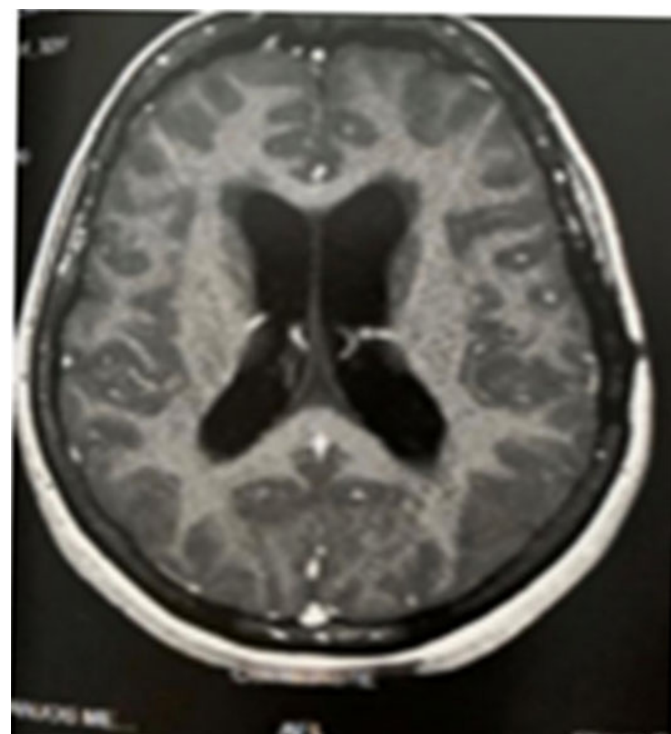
Magnetic resonance imaging showing an area of cerebral ischemia of non-specific cause and slight dilation of the ventricular system.
